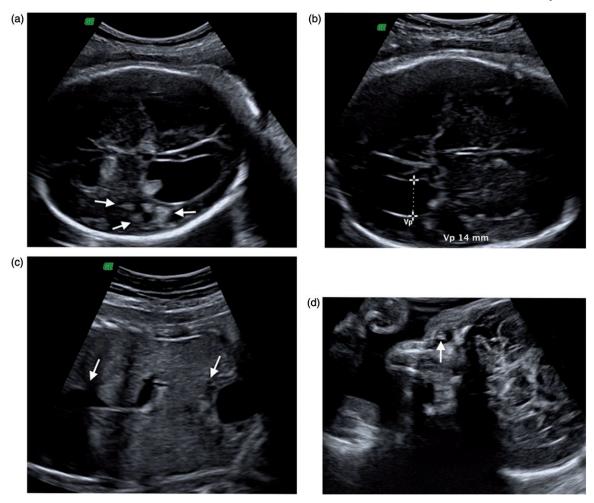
Ultrasonographic images of fetal toxoplasma infection. (a) White arrows indicate periventricular calcification, (b) ventriculomegaly; lateral ventricle width: 14.09 mm, (c) hepatomegaly; white arrows indicate liver borders from diaphragma to urinary bladder and (d) white arrow indicates the fetal cataract.
